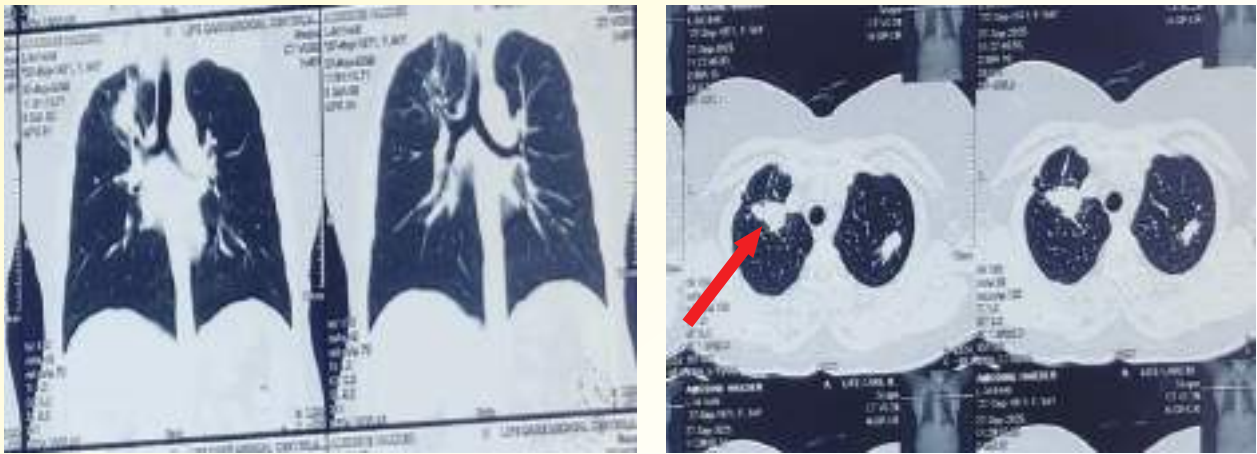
Follow-up CT chest at 3 months revealed partial reduction of lesion size.
